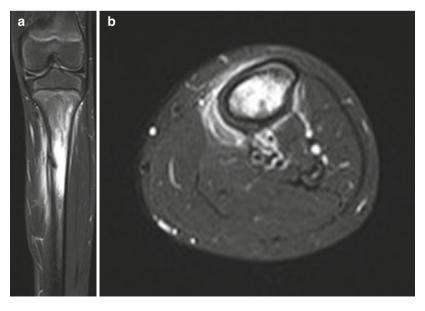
T-2 weighted MR images showing diffuse marrow edema in frontal (a) and axial view in a 12-year-old boy (b)
